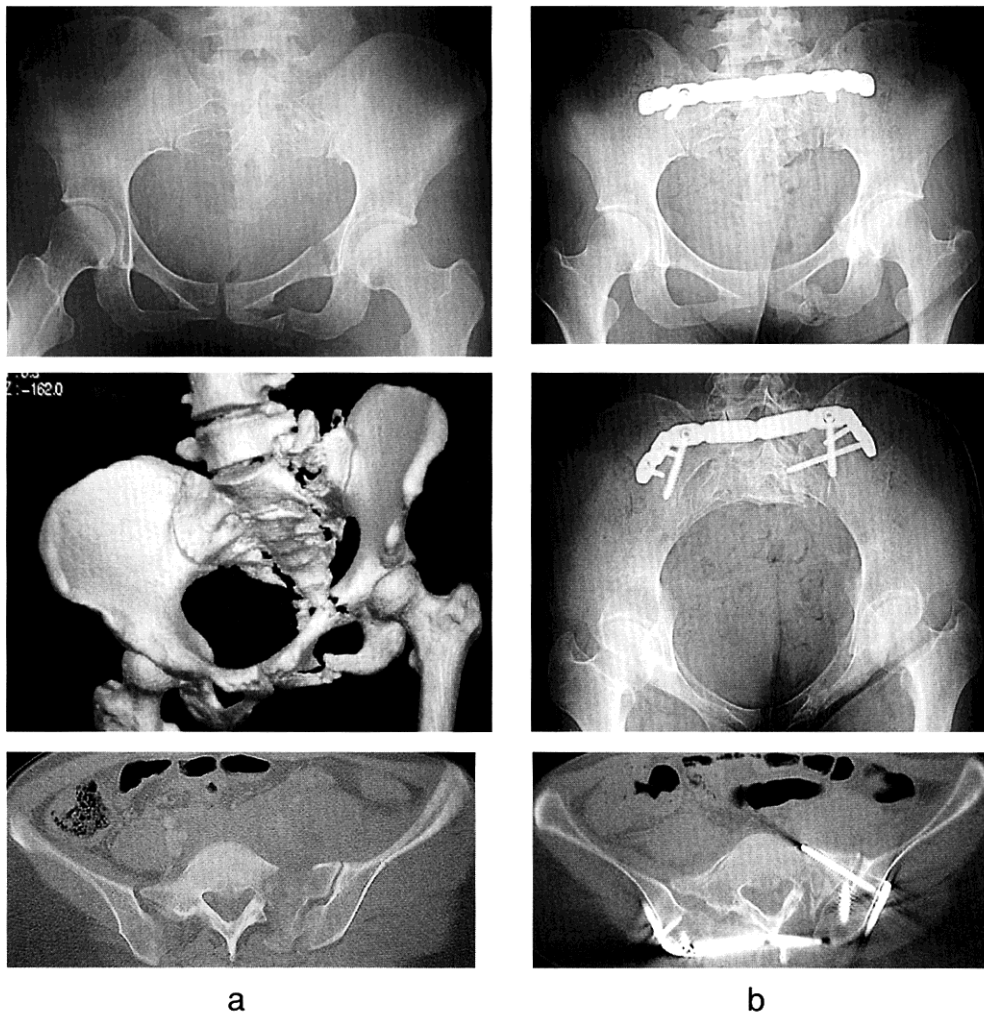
a. Preoperative AP radiography and 3D-CT, CT, sustained a Zone II sacral fracture. b. Postoperative AP and inlet radiographs and CT, fixed by M-Shaped Pelvic Plate.
